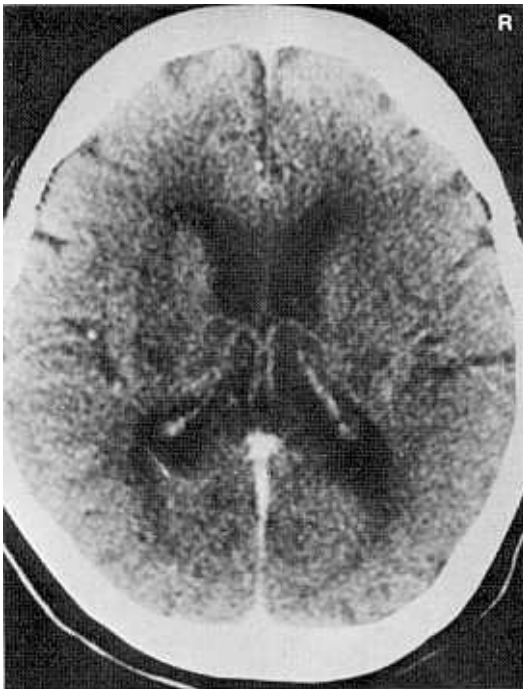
Brain CT-scan of patient 2, performed one week before HM-PAO brain SPECT, showed focal low densities in the bilateral posterolateral thalamus.
